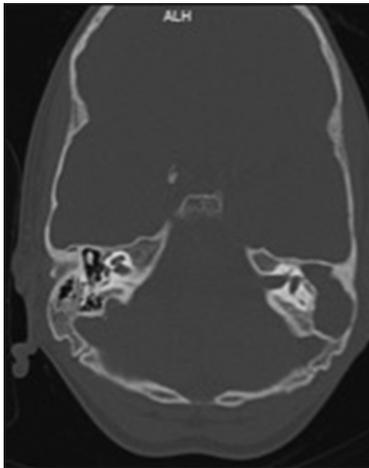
Axial HRCT image showing soft tissue mass in the middle ear cavity, aditus, and antrum with the erosion of the left middle ear ossicles
